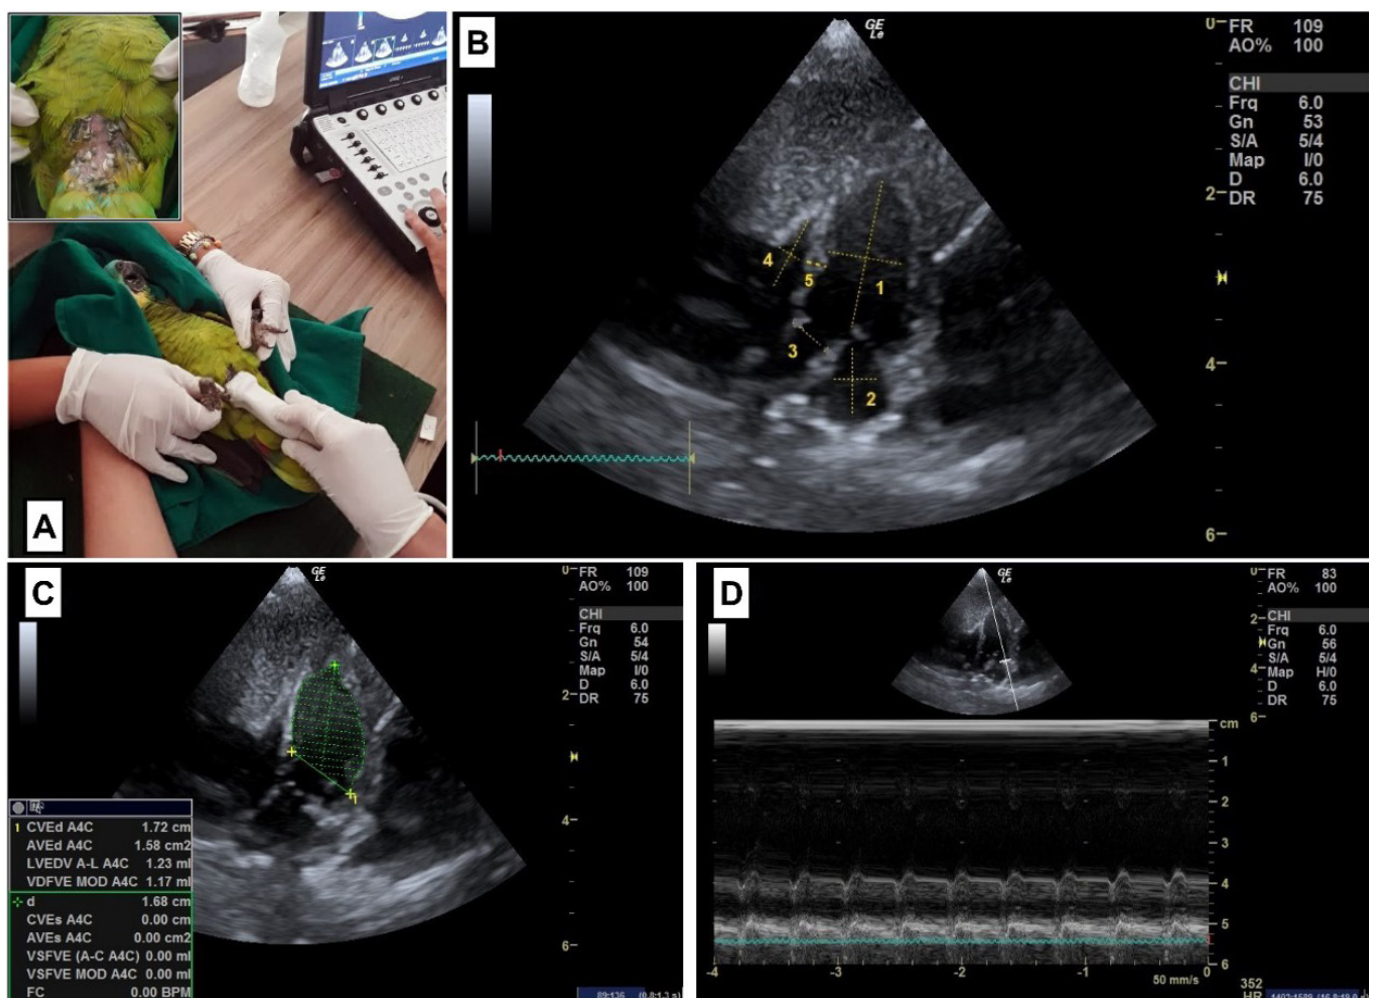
Echocardiographic of *Amazona aestiva*. (A) Positioning for the horizontal ventromedial approach. Feathers were removed from the caudal area and moved to the sternum to position the transducer; (B) Measurement of cardiac chambers using the apical four-chamber image in B-mode in the horizontal ventromedial approach. The dashed transverse lines represent the diameter, and the lines in the longitudinal direction represent the length (1: left ventricle; 2: left atrium; 3: aorta; 4: right ventricle; 5: interventricular septum); (C) Use of the Simpson method in the left ventricle; (D) Measurement of the left atrioventricular annular movement.
